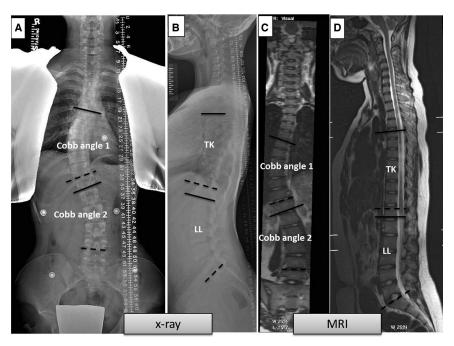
Parameters measured on radiographs and MRI total spine imaging. (A) Structural and non-structural Cobb angles on standing postero-anterior radiographs. (B) TK and LL on standing radiographs taken in sagittal plane. (C) Structural and nonstructural Cobb angles on MRI. (D) TK and LL on MRI. TK indicates thoracic kyphosis; LL, lumbar lordosis.
